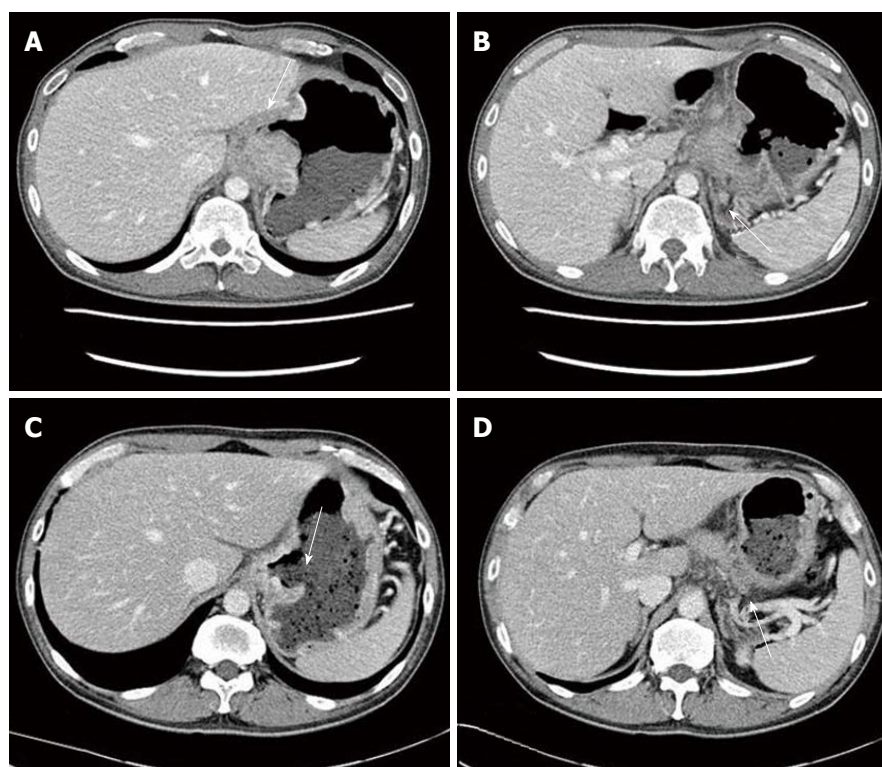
On admission, computed tomography revealed a bulky ulcerative mass with direct invasion of pancreas and left diaphragm (A and B). After 3 cycle of neoadjuvant chemotherapy (capecitabine and oxaliplatin), the mass had markedly decrease (C and D).
